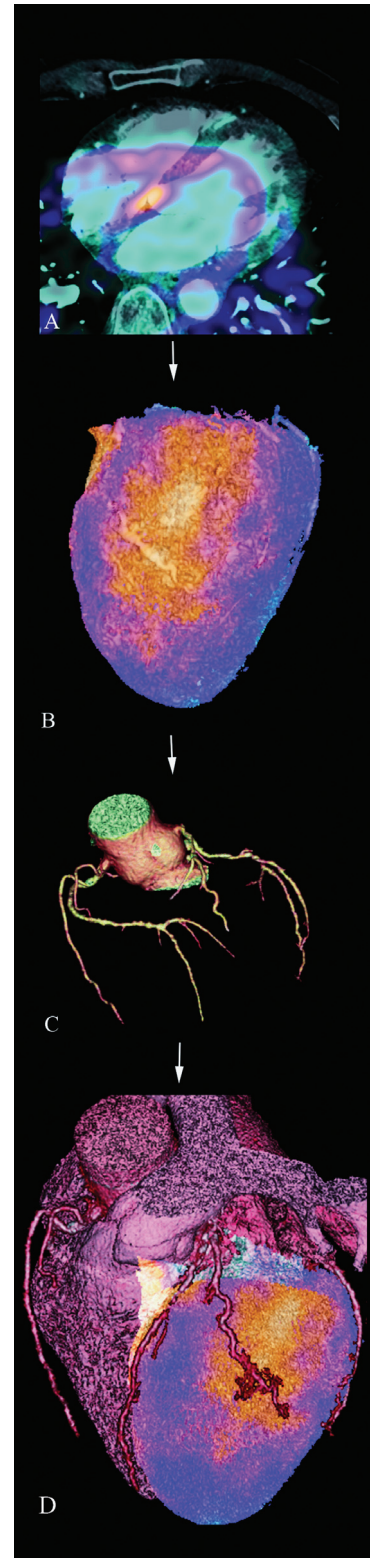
Fusion technique step by step: alignment between dual-source computed tomography and perfusion (A), definition of epicardium and vessels (B, C), and performance of the fusion of both information sources (morphology and function) (D).
